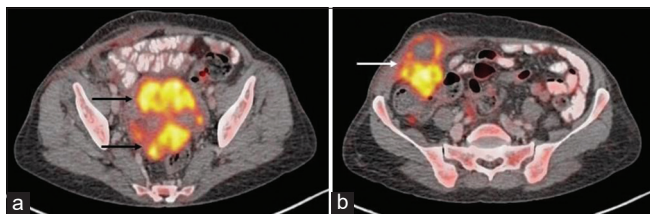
Computed tomography axial sections (a and b) of pelvis showing multiple FDG-avid enhancing lesions in the uterus (black arrows). Furthermore, note a an FDG enhancing lesion along the right anterolateral abdominal wall (white arrow).
